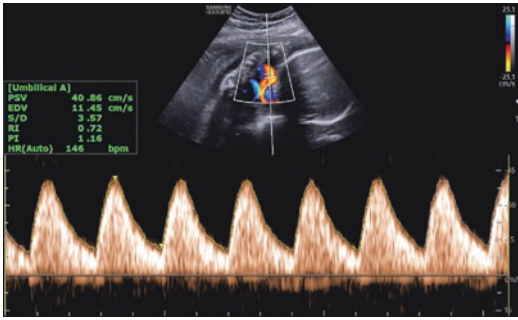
Pulsed Doppler interrogation of umbilical arteries. *Upper Panel:* Two-dimensional sonogram depicting the flow mapping of the umbilical vessels and placement of the Doppler sample volume at the umbilical arterial location. *Lower Panel:* Umbilical arterial Doppler waveforms
